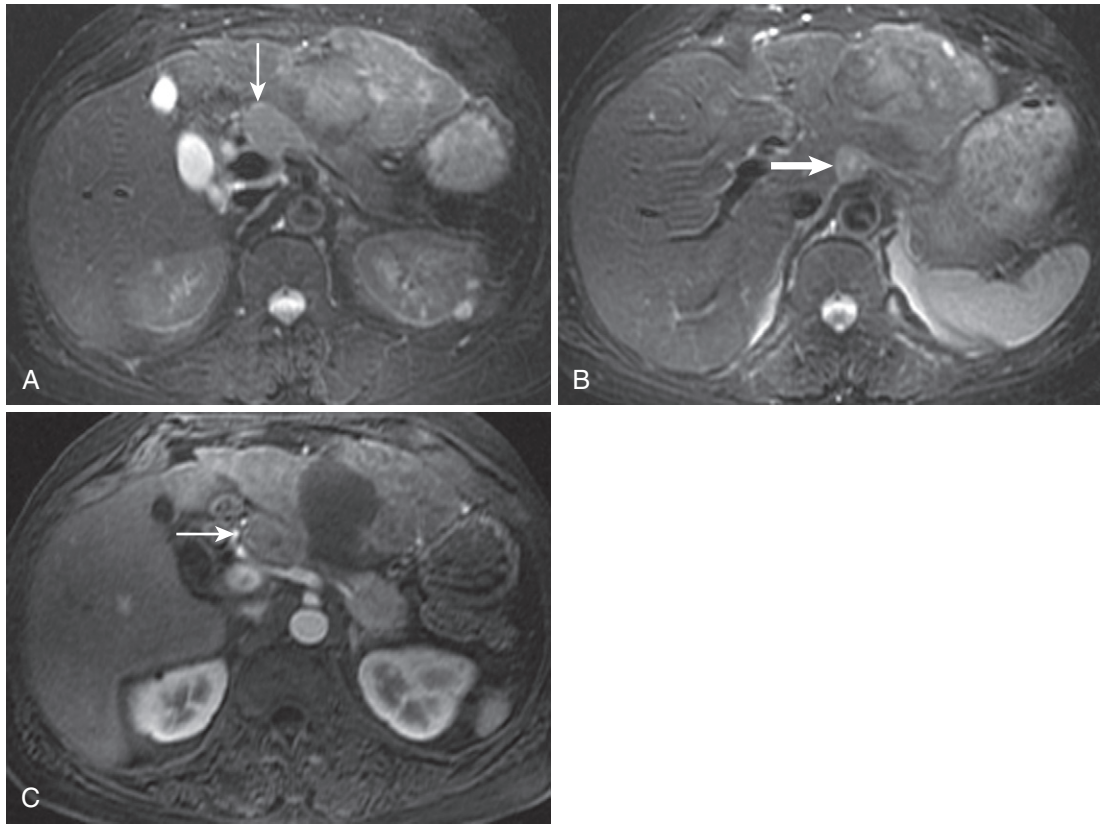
HCC with metastatic lymphadenopathy. A and B, The moderately T2-weighted images show enlarged lymph nodes in periportal (*arrow* in A) and celiac distributions (*arrow* in B) and heterogeneous hyperintensity throughout the lateral segment corresponding to a large HCC. C, The large, mildly hypervascular, necrotic HCC (*arrow*) replacing the lateral segment is evident on the arterial phase image.
